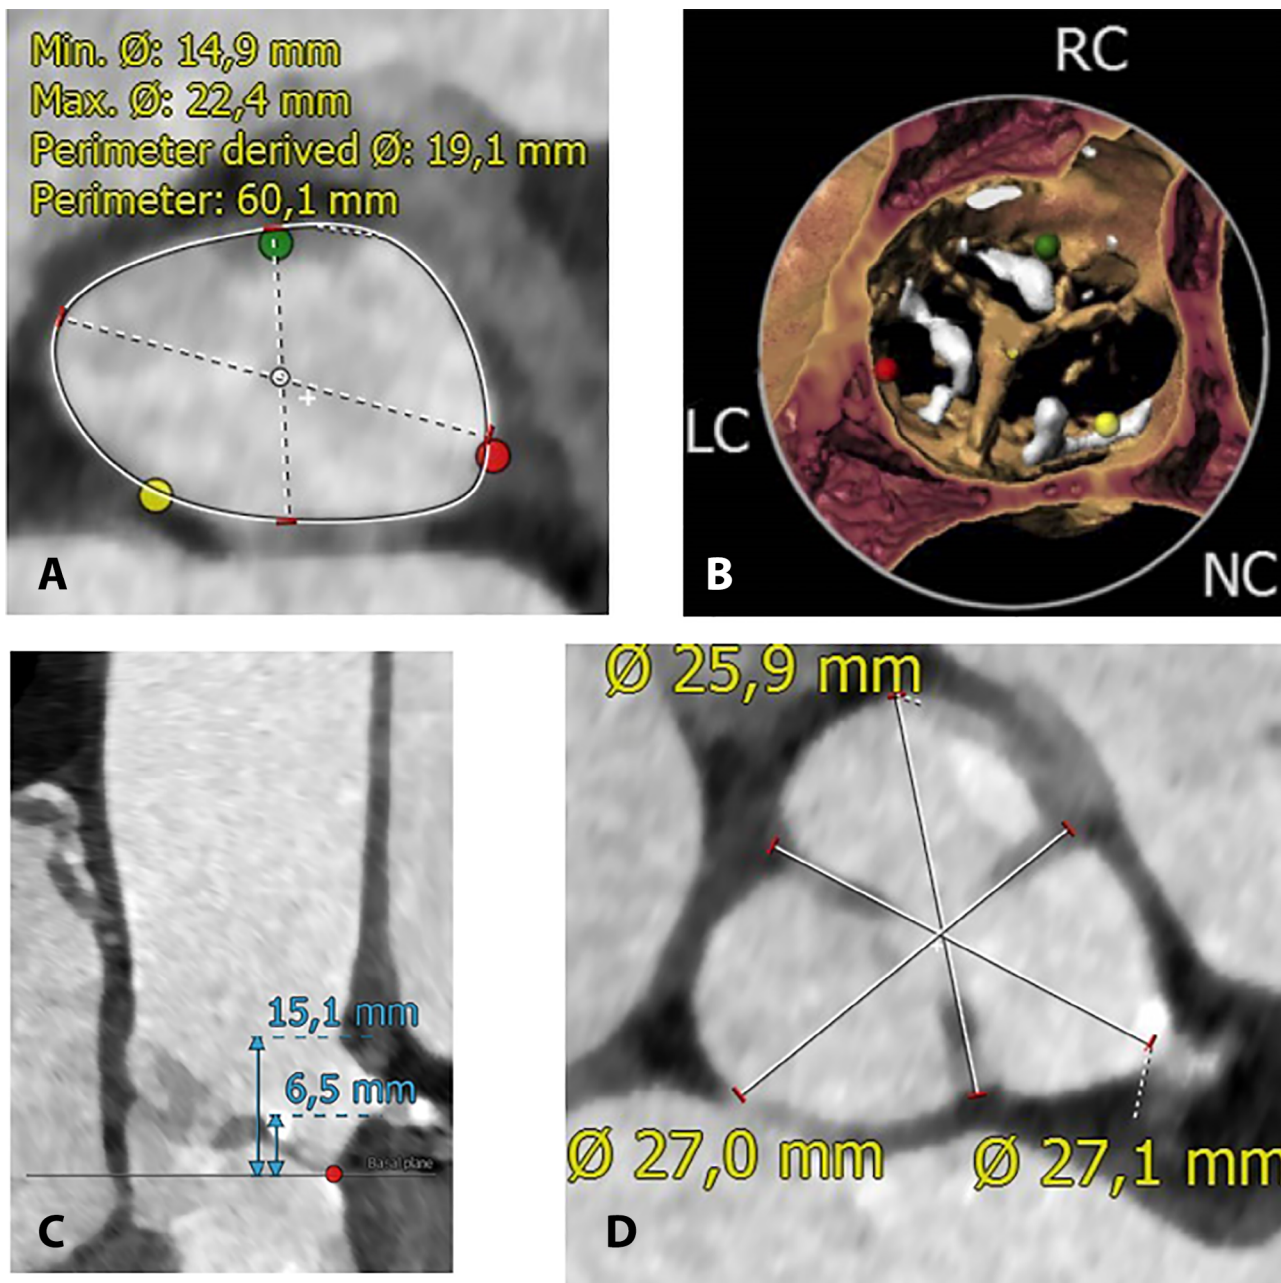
CT measurements of aortic annulus (*Panel A*), aortic leaflet calcification (*Panel B*), height of left coronary ostia/left sinus of Valsalva (*Panel C*) and diameters of sinuses of Valsalva (*Panel D*).
